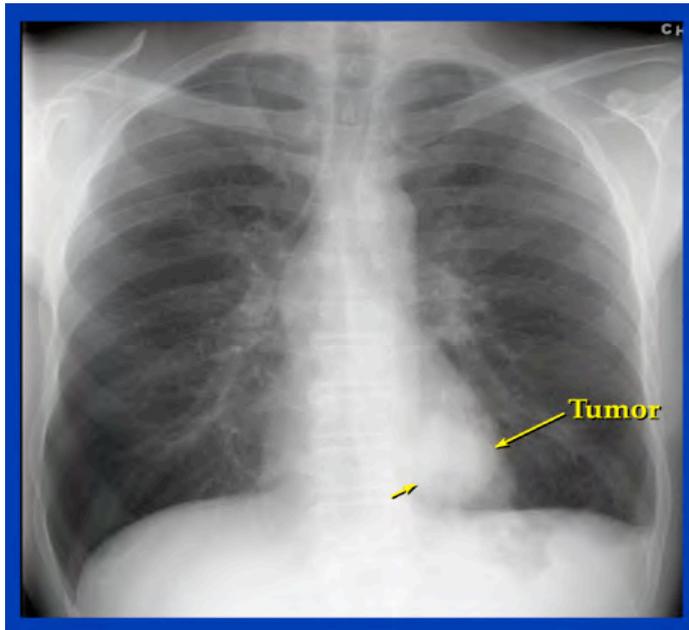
Chest X-ray and CT Scan Showing a Nodule (greater than 3 cm in diameter) without Spread to Adjacent Structures (Stage II disease).
